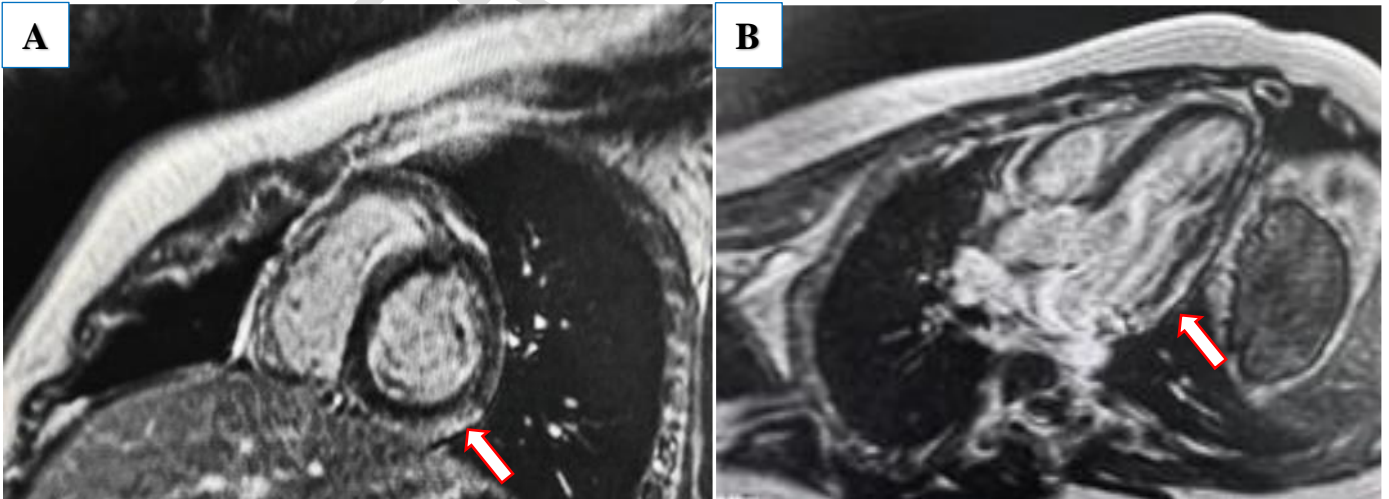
Cardiac MRI showing the presence of patchy late subepicardial gadolinium enhancement in the inferior wall (A) and the inferolateral wall (B) indicative of cardiac edema
